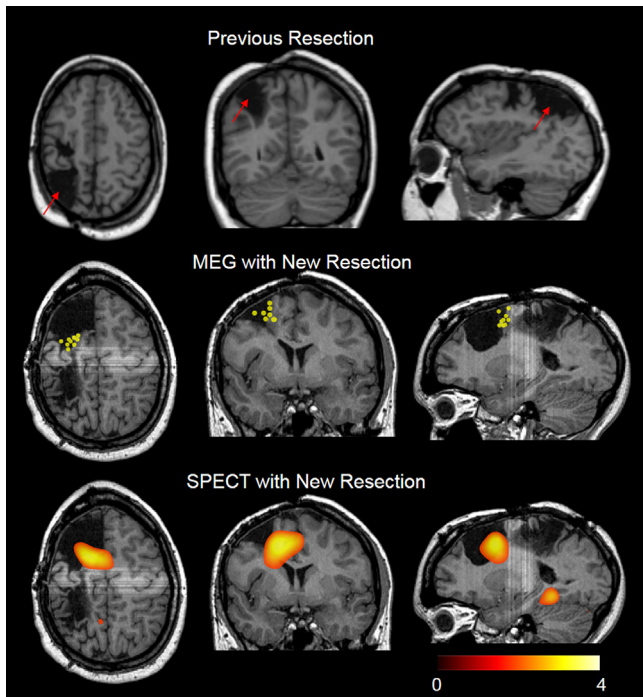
Example of a patient with right frontal lobe epilepsy, whose *ictal* MEG and *ictal* SPECT showed sublobar concordance (right superior frontal mesial). Interictal MEG was negative in this patient. The previous resection was multilobar involving right *peri*-rolandic and parietal areas. The MEG focus and the right frontal SPECT hyperperfusion zone were both resected with the new surgery, and the patient became seizure-free. Surgical pathology showed FCD type I. Injection time of the *ictal* SPECT was 9 s.
